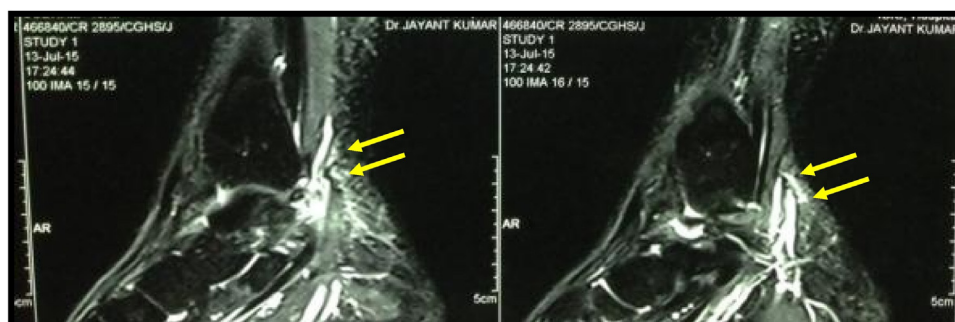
MRI showing FHL tendinitis (arrow).
